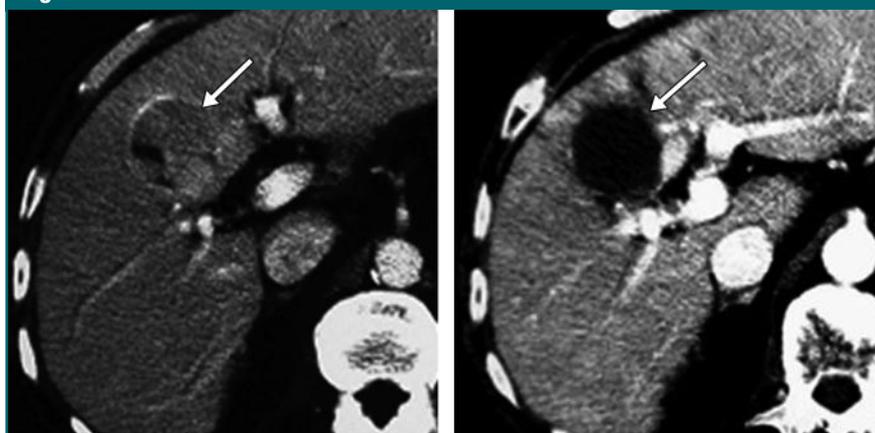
Transverse contrast-enhanced CT scans in 53-year-old male patient who underwent multipronged ethanol ablation of HCC at unfavorable location. (a) Preablation scan (portal phase) shows 4.0 \times 4.2-cm tumor (arrow) located close to porta hepatis. (b) Scan obtained 1 month after ethanol ablation (one session, 35 mL of ethanol injected) shows hypoattenuating ablation zone completely enveloping target tumor site (arrow, portal phase).
